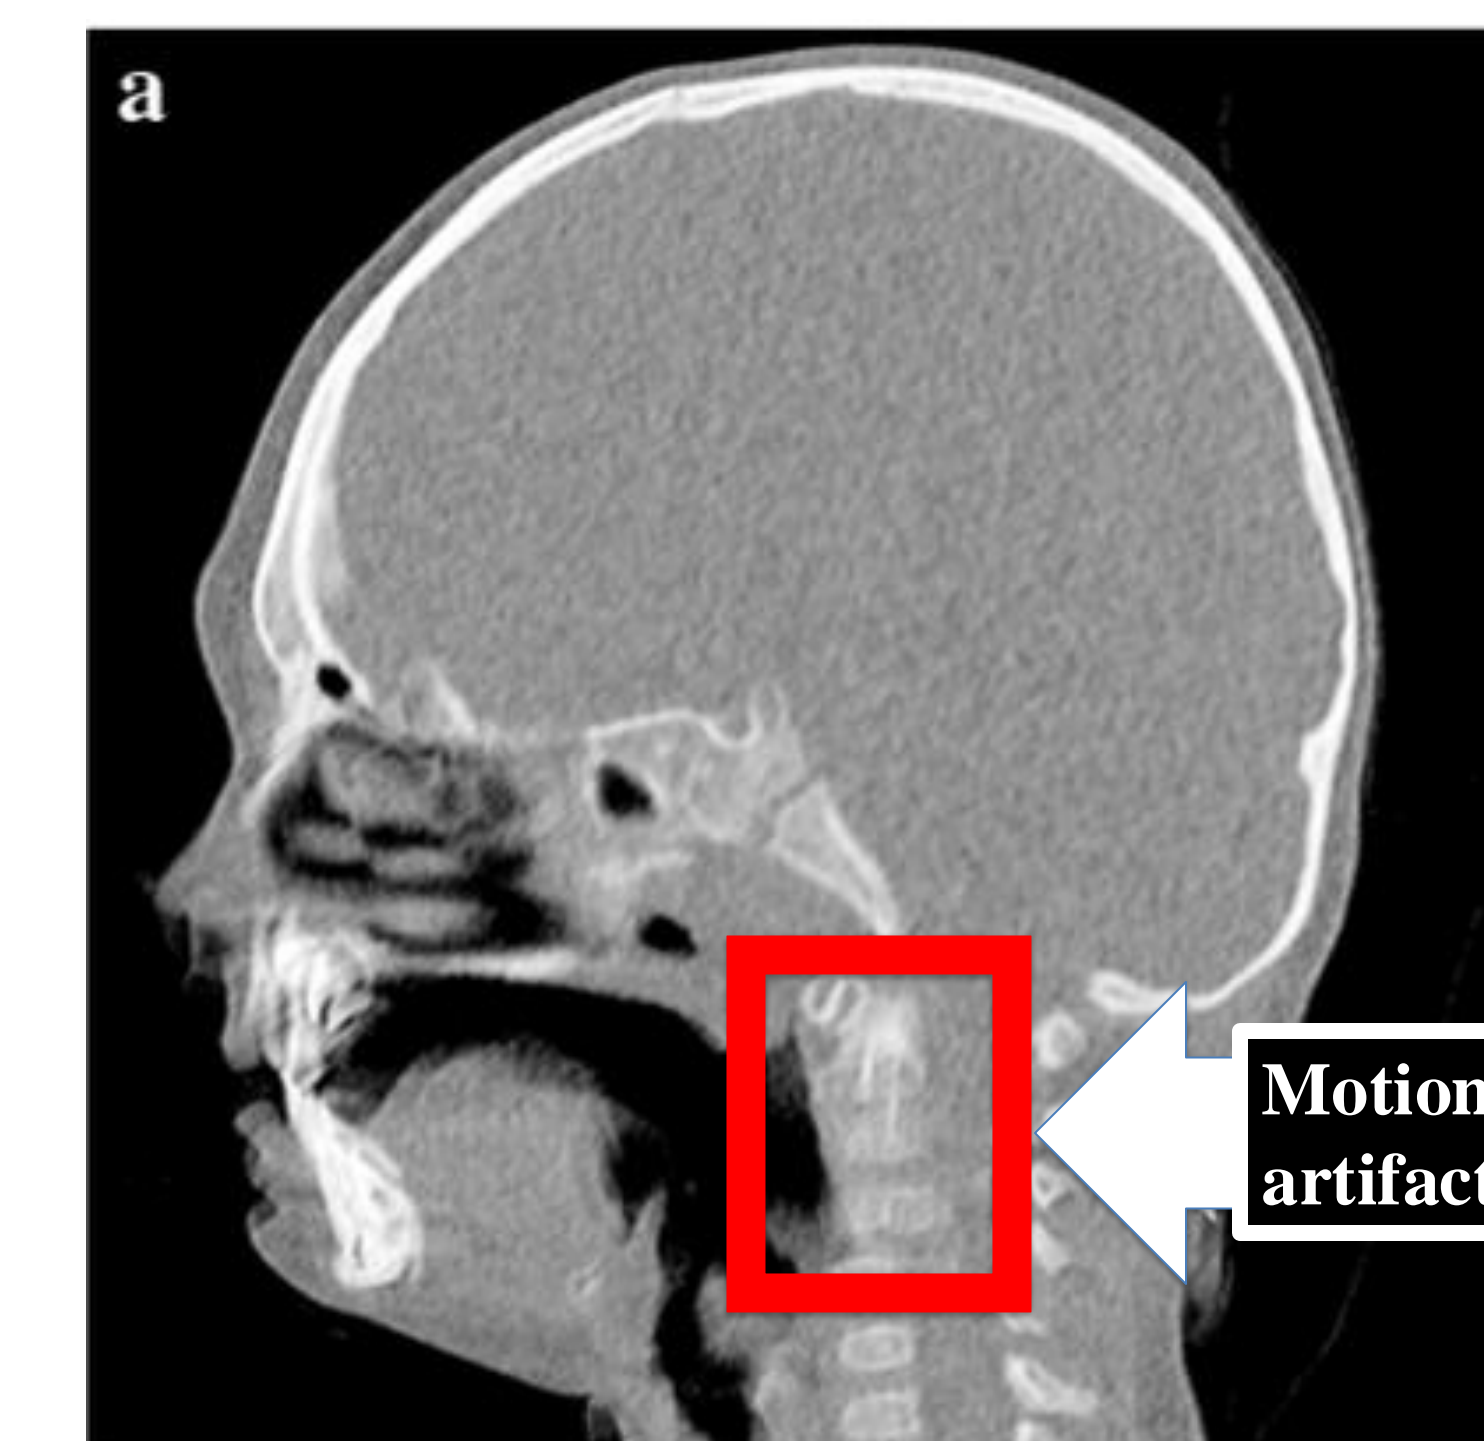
This sagittal CT image demonstrates motion artifact of the anterior portion of the cervical spine. Motion artifact makes the diagnosis process for radiologists difficult to distinguish between abnormalities and normal findings during CT studies (Barreto et al., 2021, p. 92).
